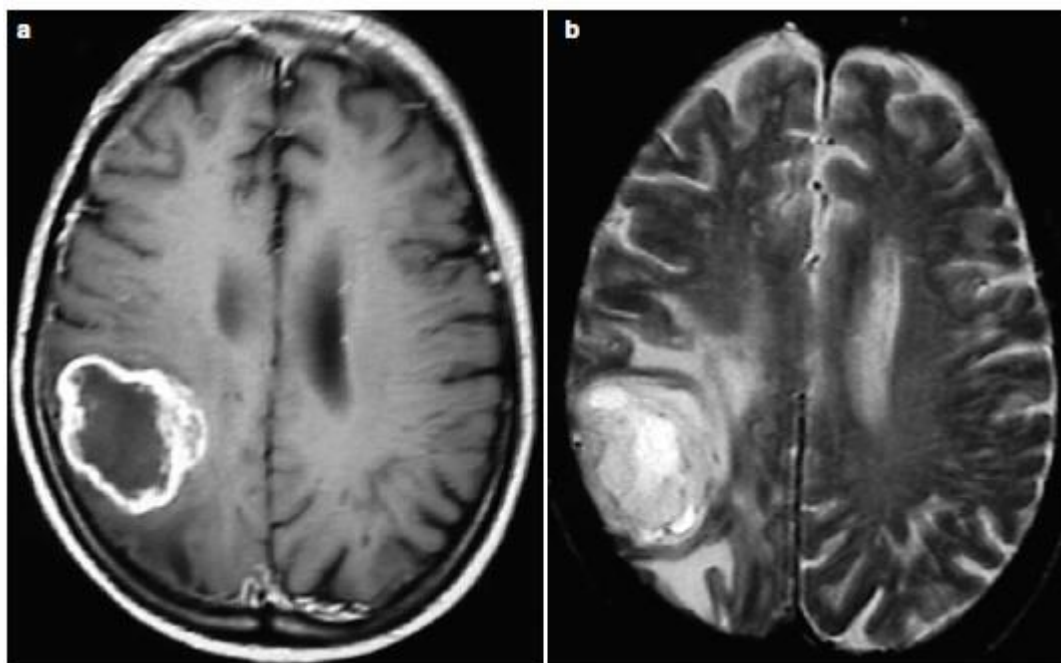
Magnetic resonance imaging of Glioblastoma. GBM in right parietal lobe a) Post contrast T1-weighted image
